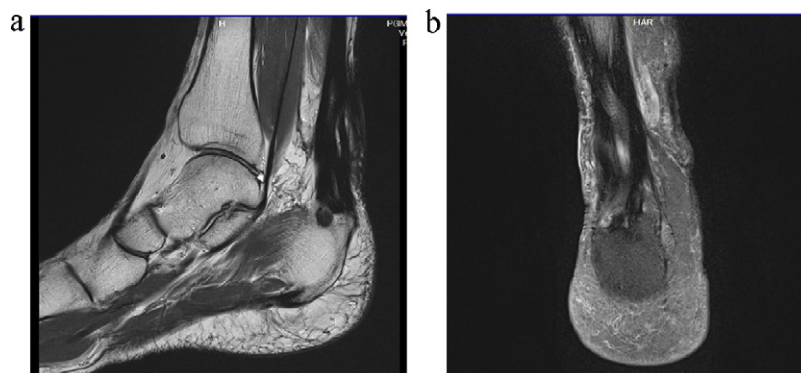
Postop MRI – T1-weighted sagittal and coronal cuts showing good bio-integration of LARS ligament.
